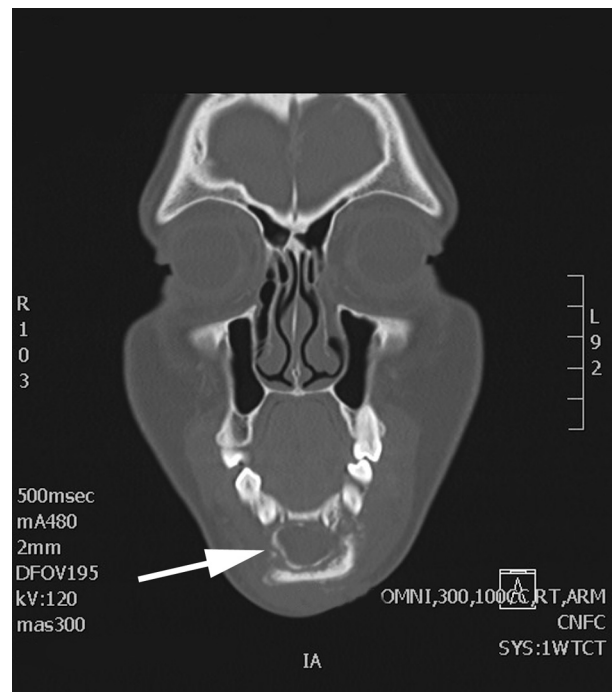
Coronal CT view demonstrating erosion of the buccal plate (arrow) and the bone supporting the lower incisors.
